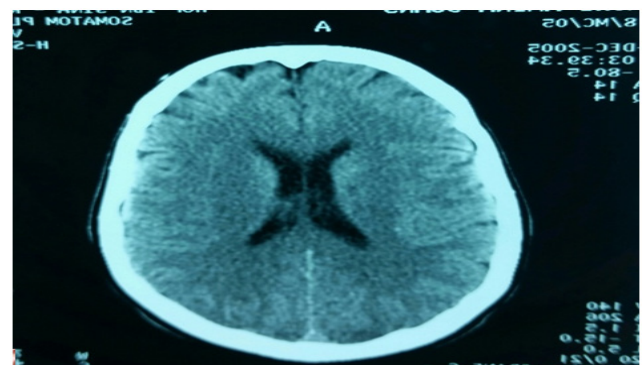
Cranial CT scan normal, without abnormalities.
